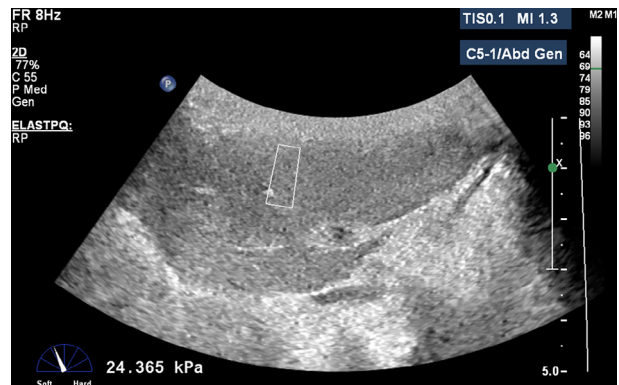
In vivo* stiffness measurements. Stiffness measurement of one liver lobe displayed over B-mode ultrasound images. The white box represents the region of interest for stiffness measurement.
